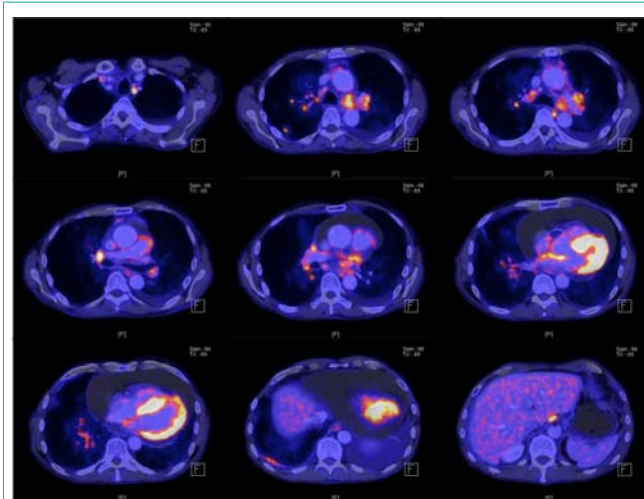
PET-CT detecting extensive metabolically active diffusely spreading tumor manifestations with the left hilar primary tumor, lymphangiosis carcinomatosa on both sides, pleural and pericardial involvement, and multiple lymph node metastases in the mediastinum, both sides of the hilum, and in the cervical and abdominal areas. Tumor stage was identified to be T4N3M1a. Furthermore, pulmonary embolism and progressive, severe pericardial effusion was found.
